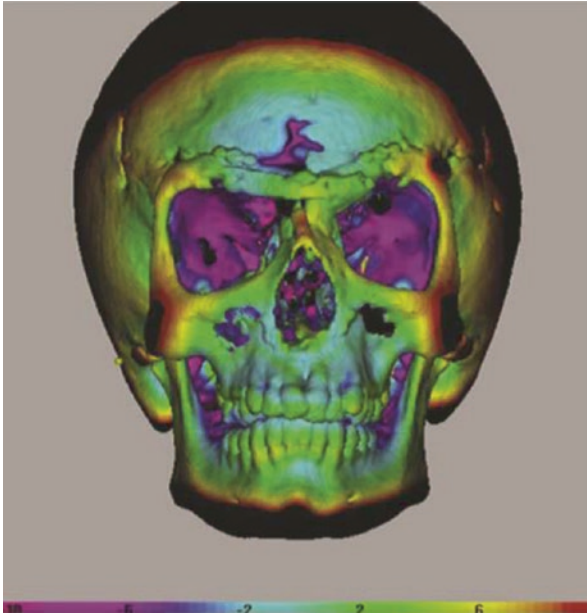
Geometric morphometric colour map of postoperative versus expected normal 3D CT scan. Frontal view depicts positive and negative surface differences. *Light blue* and *green* areas show correspondence between the postoperative and normal scans. Figure reproduced with permission from Crombag et al. 2014
